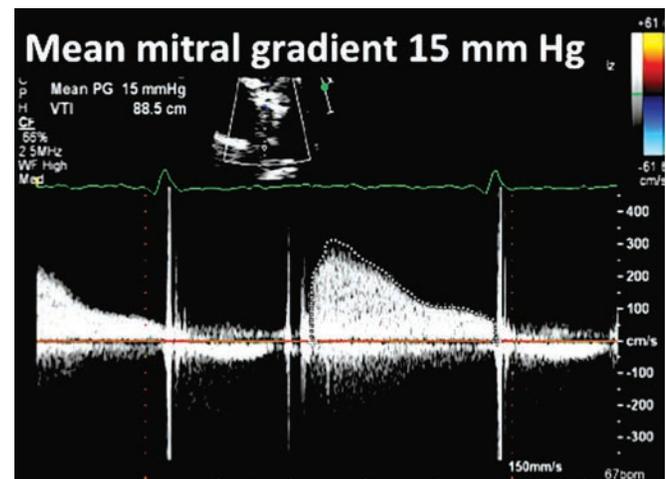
Continuous wave Doppler of the prosthetic mitral valve. One clue to prosthetic valve thrombosis is elevated prosthetic gradients. Continuous wave Doppler of the prosthetic mitral valve demonstrates a gradient of 15 mmHg, consistent with severe mitral stenosis.
